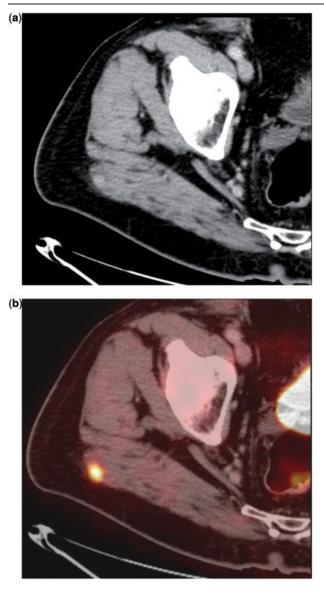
A 45-year-old man with cancer of the colon. (a) Metastasis to the gluteal muscle is very subtle on CT. Muscular metastases are often seen as small enhancing nodules, only on retrospective analysis. (b) The lesion is more clearly demarcated on PET/CT.
